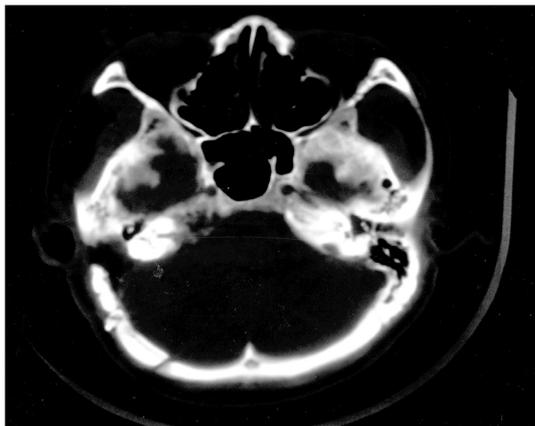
Axial view of posterior fossa CT scan shows post-operative state after 3 months. Right lateral semicircular canal and middle ear cavity were intact. There was no evidence of recurrence.
